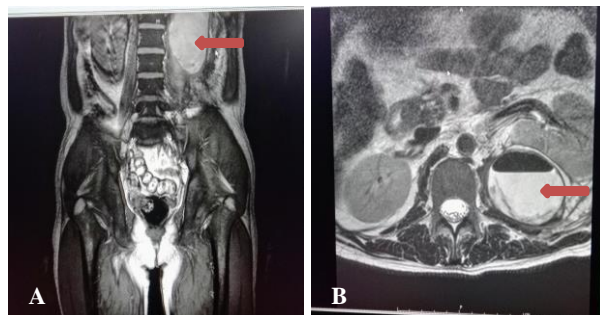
(A) Coronal, (B) Axial T2 weighted MRI images through the abdomen at the level of the kidneys show a well-defined hyperintense lesion.
